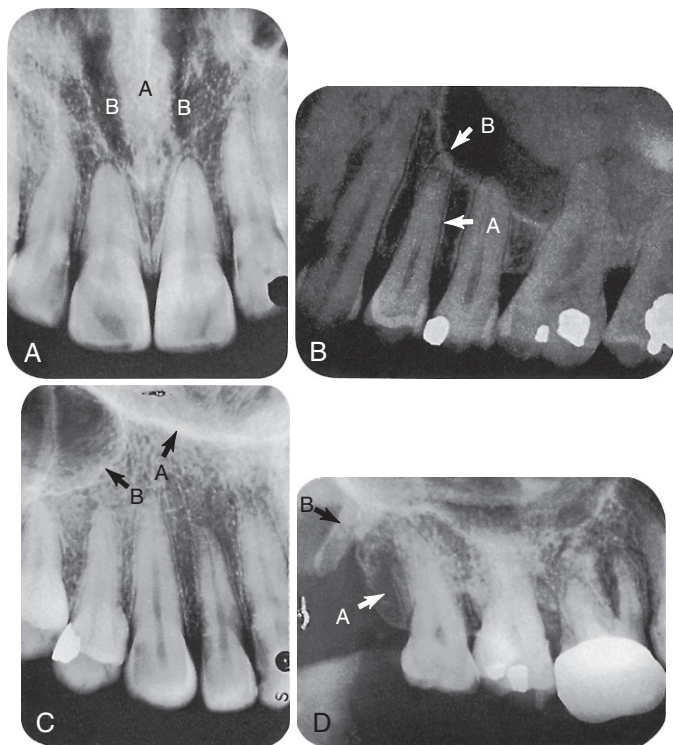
I A, Radiograph of central incisor region visualizing the nasal septum (A) and fossae (B). B, Radiograph demonstrating the normal appearance of the lamina dura (A) and the periodontal membrane (B). C, Radiograph depicting the Y (inverted) formed by the junction of the lateral wall (A) of the nasal fossa and the antemedial wall (B) of the maxillary sinus. D, Radiograph visualizing the tuberosity of the maxilla (A) and the hamular process of the sphenoid bone (B).
